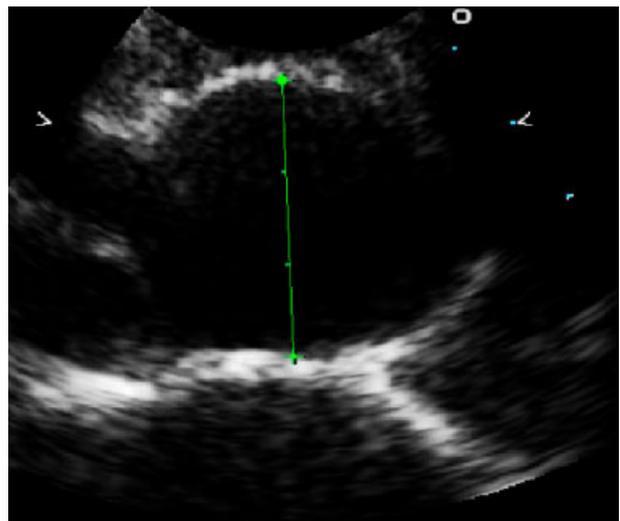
Dilated proximal aorta with a measured diameter of 3.1 cm in a 15-year-old boy with EDS, as seen in a left parasternal long axis view.
